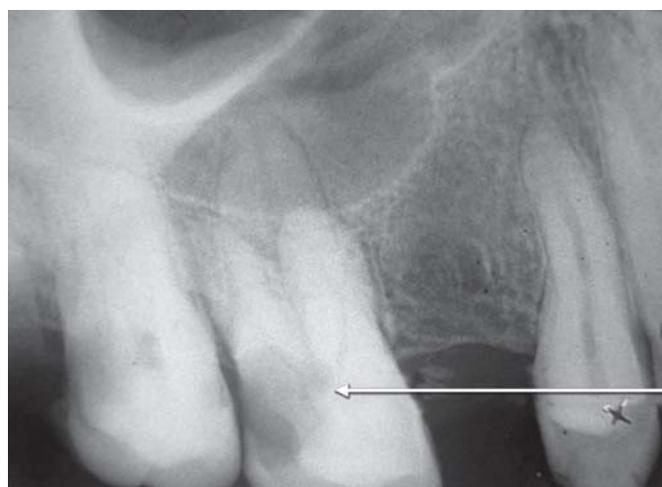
Radiograph showing proximal caries involving the pulp and presence of large pulp stone obliterating the pulp chamber in maxillary molar (case 2)
